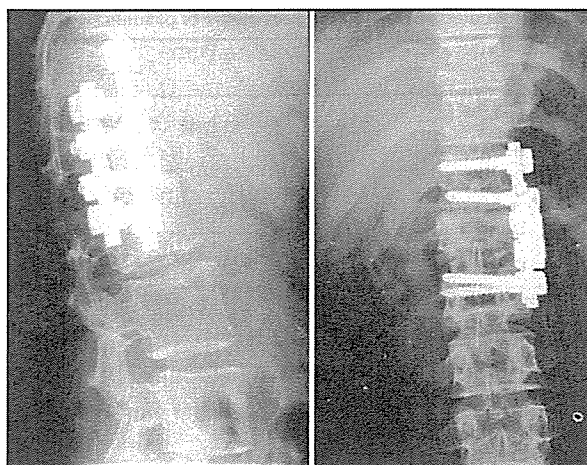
Postoperative AP and lateral x-ray, 9 months after the operation with anterior approach.
